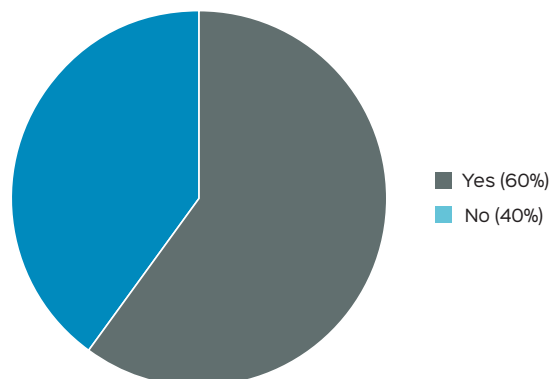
ARE DRINKING FOUNTAINS INSPECTED YEARLY FOR WATER QUALITY? (25 RESPONSES)
